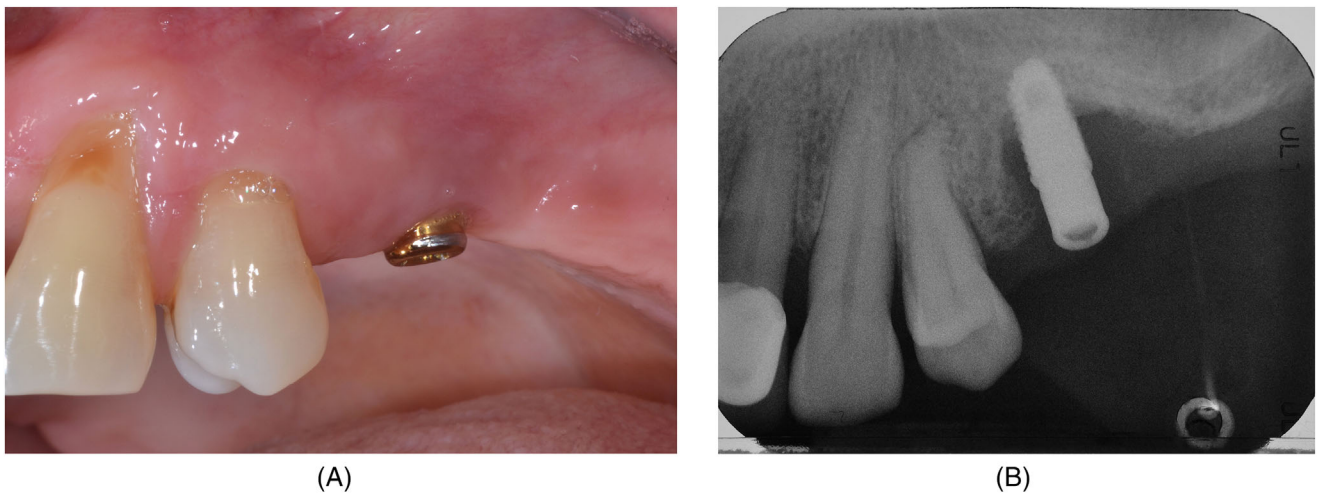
For the implant on the left (A), a diagnosis of peri-implantitis was based on the presence of bleeding and suppuration on gentle probing, and radiographic bone loss around the implant surface for approximately half of its length (B).
